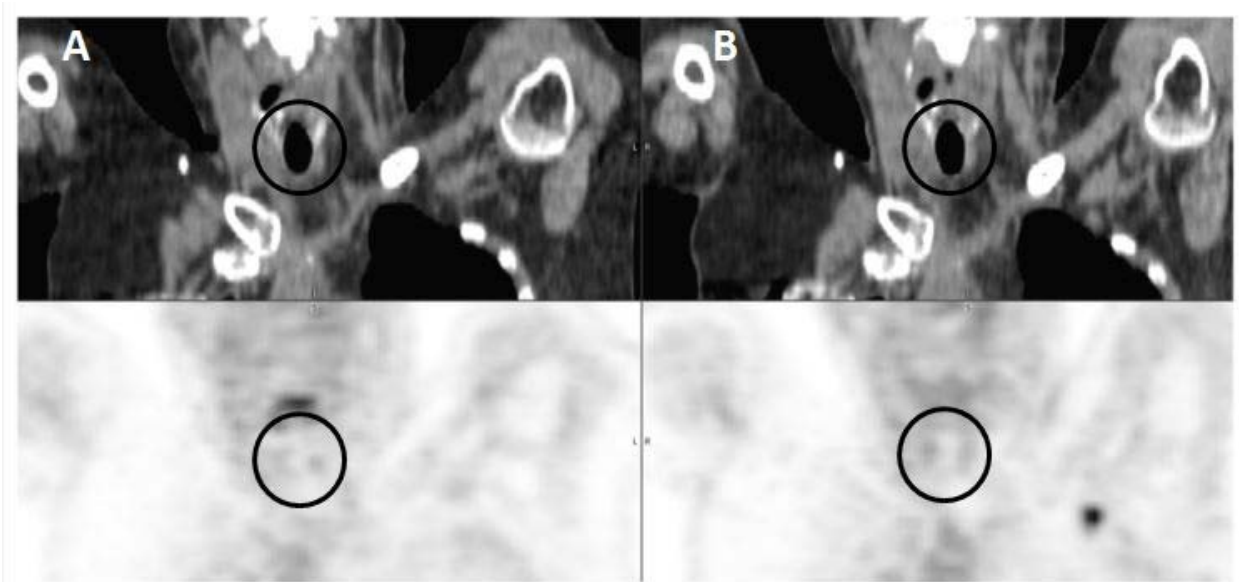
Patient with normal ^{18}F -FDG uptake in thyroid gland during nivolumab therapy. Coronal images from the pre-therapy (A), CT (top left) and ^{18}F -FDG PET (bottom left) displayed normal uptake in the thyroid gland with $\text{SUV}_{\text{max}} = 2.2$. Coronal images from the during therapy (B), CT (top right) and ^{18}F -FDG PET (bottom right) showed increased thyroid uptake with $\text{SUV}_{\text{max}} = 1.8$. Black circle denotes the region of the thyroid gland.
